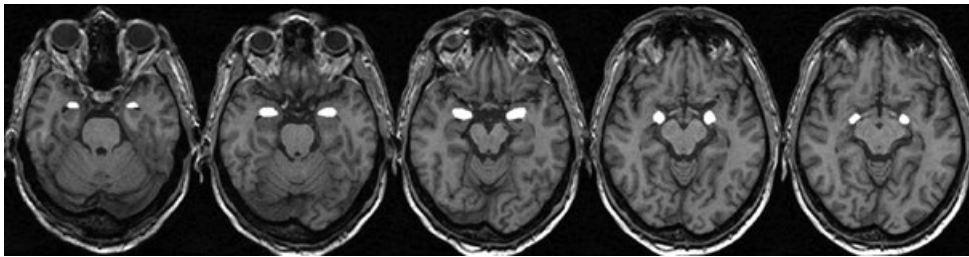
The output of the automated segmentation of the right and left amygdala is shown on transverse MRI slices exemplary for one study participant. Right and left amygdala are shown in white color.
